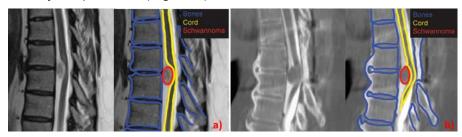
A 56 yo female presents with progressive lower extremity weakness, numbness, and spasticity and worsening bowel and bladder function. MRI of the thoracic spine demonstrates a mass resulting in severe compression of the spinal cord. Figure 1b. Resection of this lesion yielded a schwannoma. Two years later, the patient presents with recurrent
